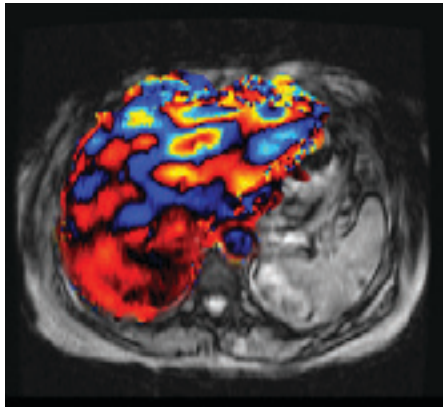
MRI with color coded wave.
